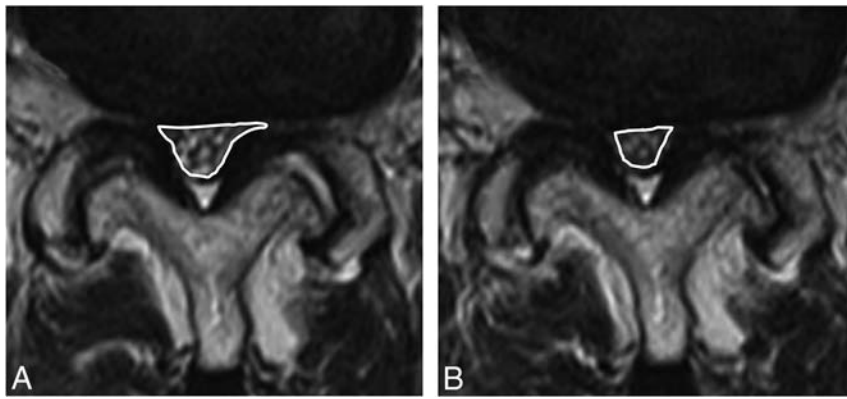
Measurement of the DCSA on conventional MR imaging and axial-loaded MR imaging in a representative case. The *white lines* indicate the outlines of the DCSA. The DCSA changed from 67 (A) to 41 mm² (B) due to axial loading.
